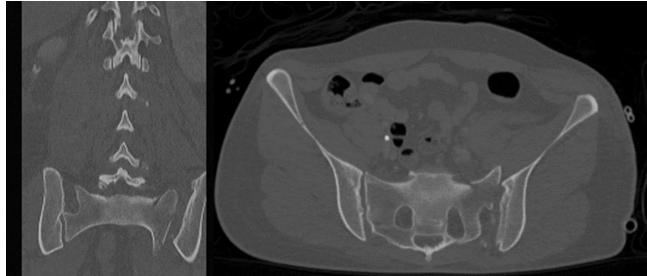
Coronal and axial CT cuts showing marked asymmetry between the left and right sacroiliac joints and left sided sacroiliac fracture dislocation.
